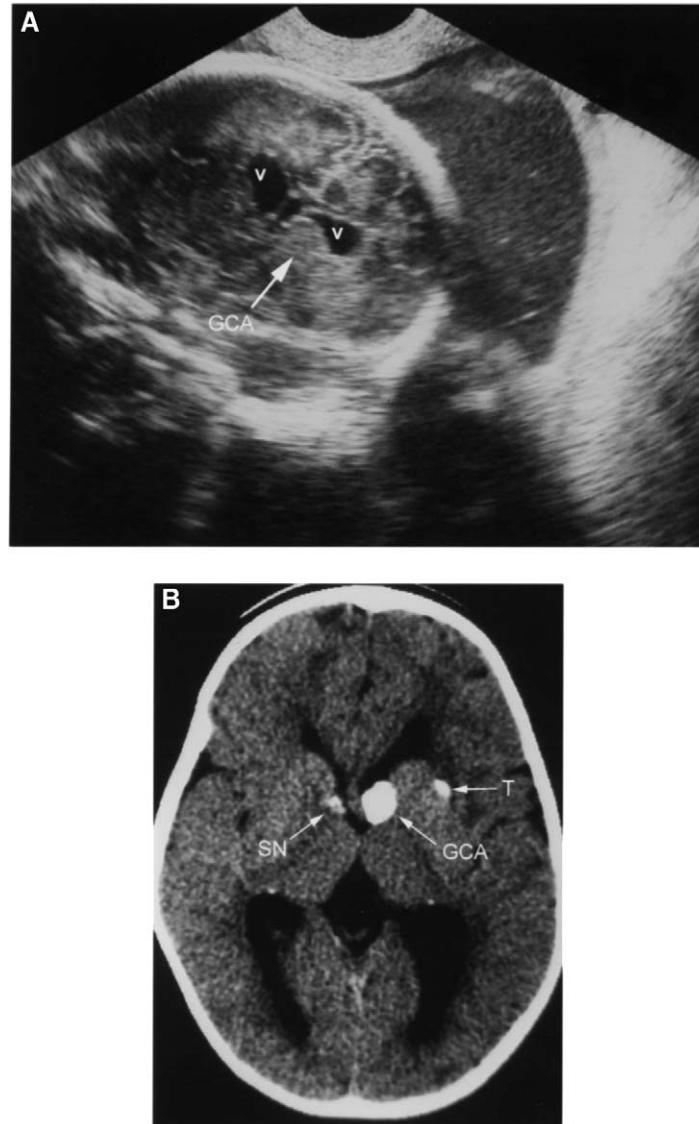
(A) Prenatal ultrasound of fetal brain at 30 weeks' gestational age in coronal plane through the anterior fontanelle. The anterior horns of the lateral ventricles (V) are dilated. There is an abnormal mass (giant cell astrocytoma, GCA) arising from the caudate nucleus area and indenting the ventricle close to the Monro foramen. (B) Axial computed tomography scan at age 24 months confirms the mass, which was shown to be a GCA by the Monro foramen. Additional lesions are also visible (SN, subependymal nodule; T, insular tuber). All the masses show calcification at this time.
